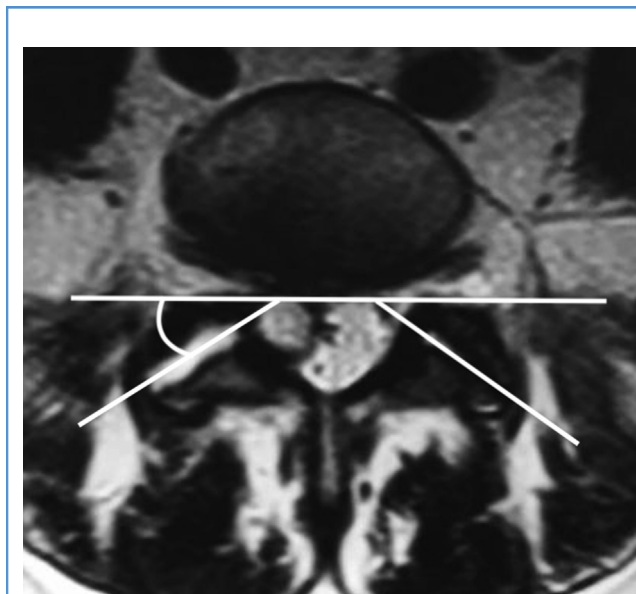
Axial T2-weighted magnetic resonance image showing coronal facet inclination angle on the side of the cyst.
